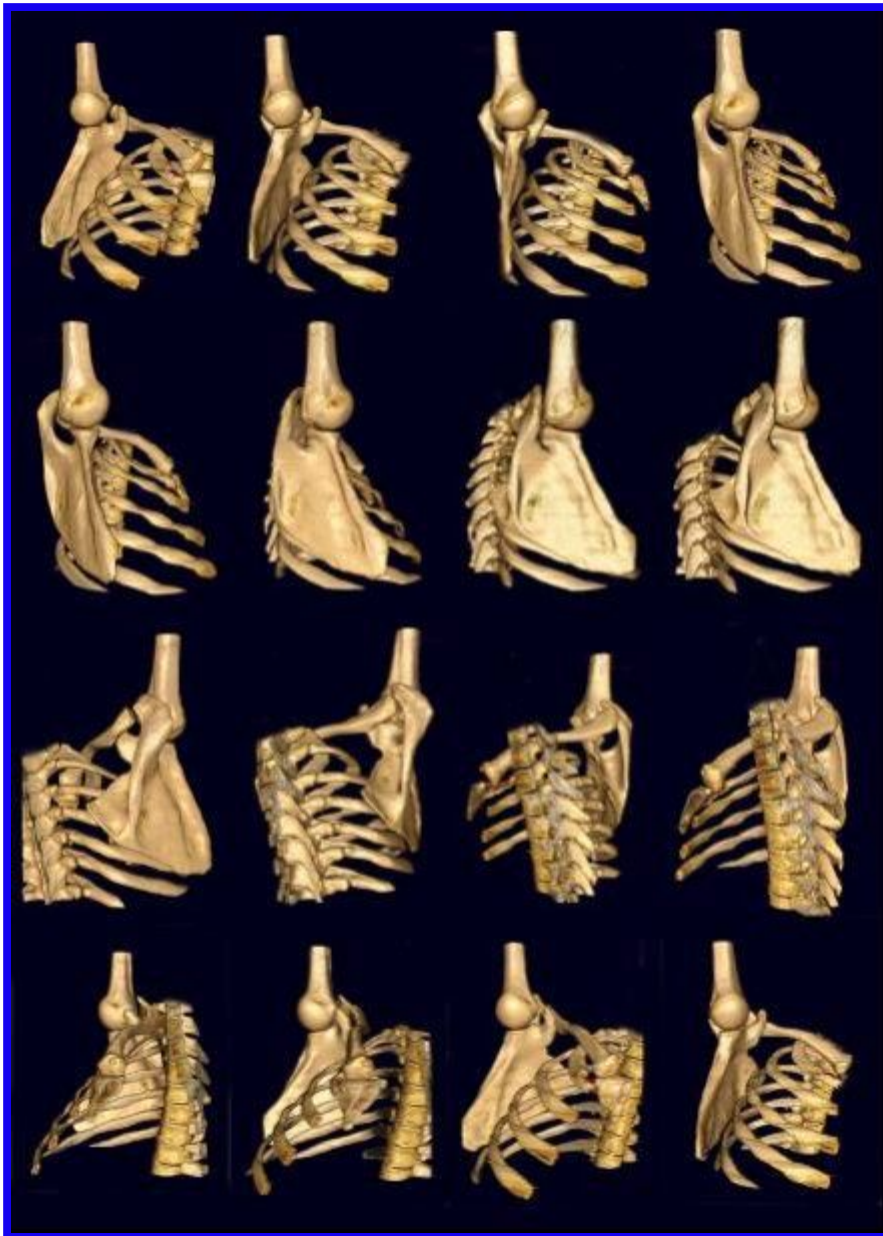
The rotating skeleton with the shoulder in the hanging position taken from a CT scan.
